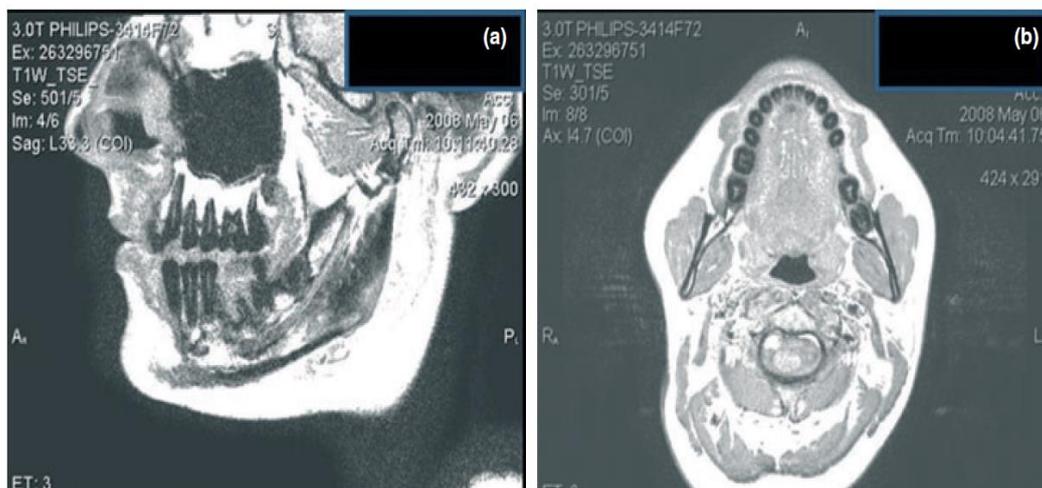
Figure (a) A sagittal MRI scan of the head. Bone and teeth do not give a signal and therefore appear dark. The root canals can be clearly visualized, as can the maxillary root apices relationship to the maxillary sinus. (b) An axial MRI scan, the soft tissues can be clearly identified. Courtesy of Dr Crawford Gray, Aberdeen, UK.^[23]
